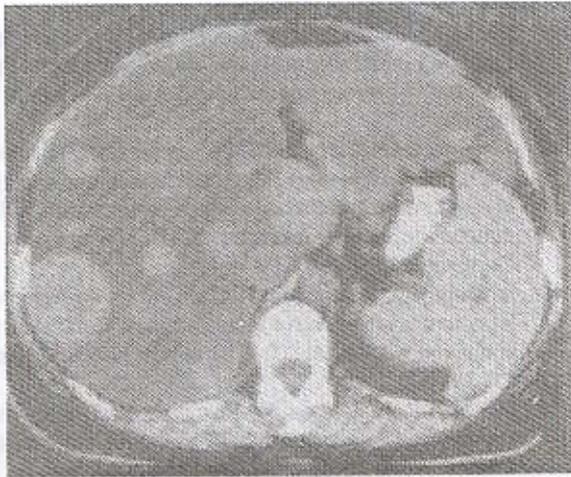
Abdominal CT scan 6 months after the operation shows multiple liver metastases.
